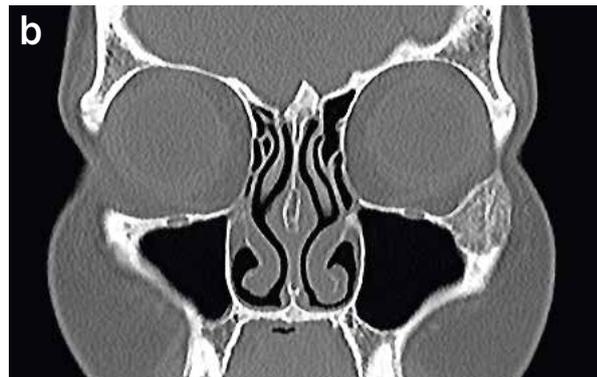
The CT scan shows a lesion in the left zygoma sized 23 x 19 x 14 mm. The corticalis is thinned; the surrounding soft tissues are unaltered (arrow)
